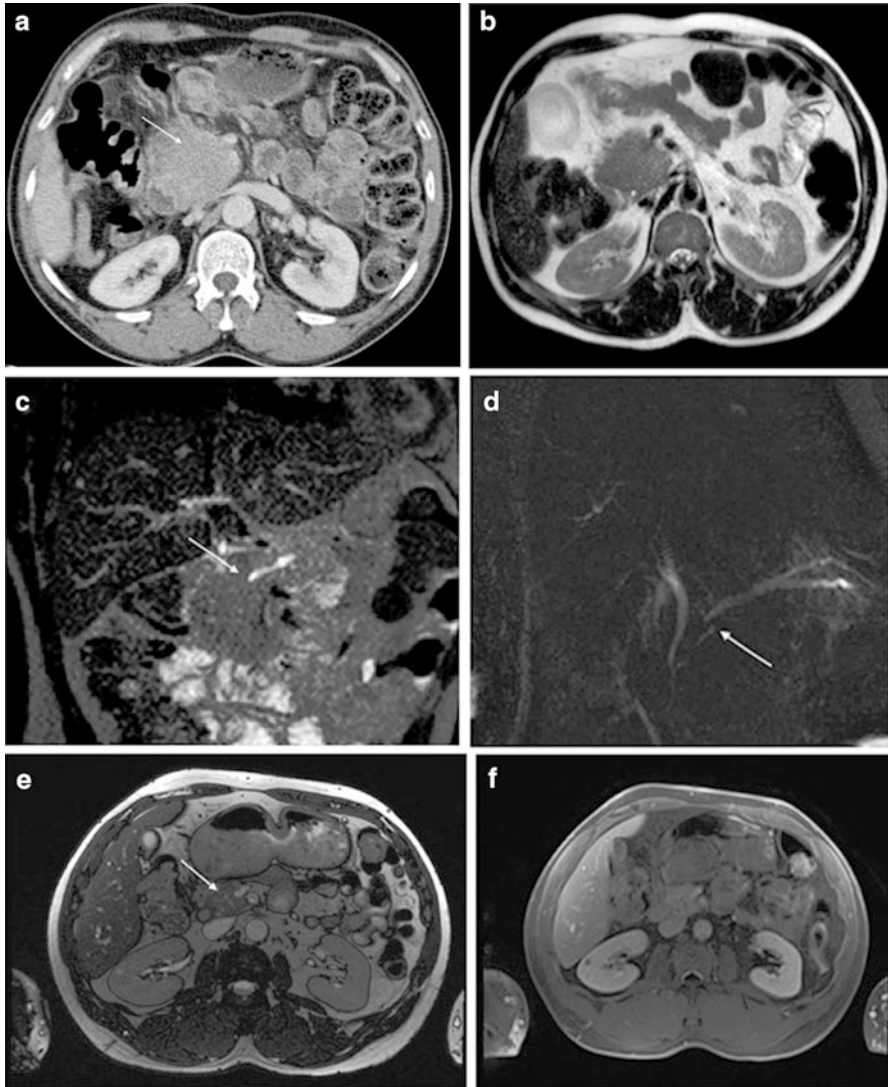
Selective images of a mass forming AIP pre and posttreatment. (a) Axial contrast enhanced CT scan demonstrating a slightly hypodense expanded pancreatic head (*white arrow*) in keeping with a mass. (b) Axial T2 weighted sequence of the head of pancreas which is slightly higher signal than muscle. (c) Coronal T2 weighted sequence demonstrating the high signal pancreatic duct penetrating the mass (*white arrow*). (d) MRCP sequence demonstrating the dilated pancreatic duct with a tapering and penetrating into the pancreatic head (*white arrow*). (e) Axial T2 weighted scan of the pancreatic head which appears normal in size with a normal pancreatic duct (*white arrow*), 4 weeks post-steroid treatment. (f) Axial portal venous phase scan of a normally enhancing pancreatic head (Images courtesy of Dr. R Albazaz, Leeds Teaching Hospital NHS trust)
